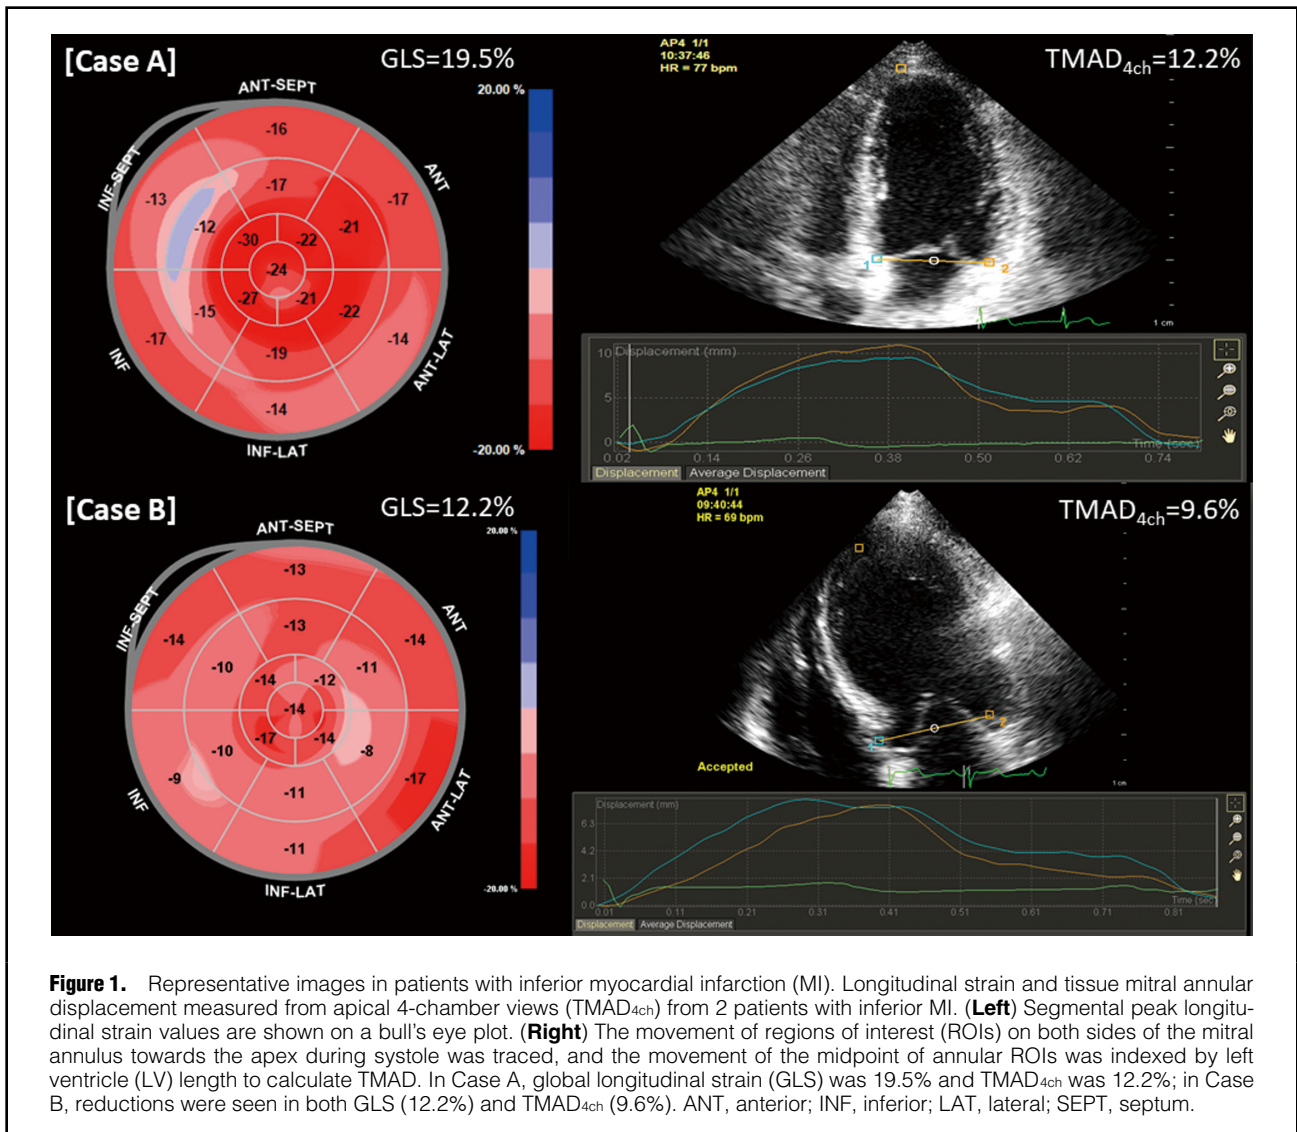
Representative images in patients with inferior myocardial infarction (MI). Longitudinal strain and tissue mitral annular displacement measured from apical 4-chamber views (TMAD_{4ch}) from 2 patients with inferior MI. (Left) Segmental peak longitudinal strain values are shown on a bull's eye plot. (Right) The movement of regions of interest (ROIs) on both sides of the mitral annulus towards the apex during systole was traced, and the movement of the midpoint of annular ROIs was indexed by left ventricle (LV) length to calculate TMAD. In Case A, global longitudinal strain (GLS) was 19.5% and TMAD_{4ch} was 12.2%; in Case B, reductions were seen in both GLS (12.2%) and TMAD_{4ch} (9.6%). ANT, anterior; INF, inferior; LAT, lateral; SEPT, septum.
